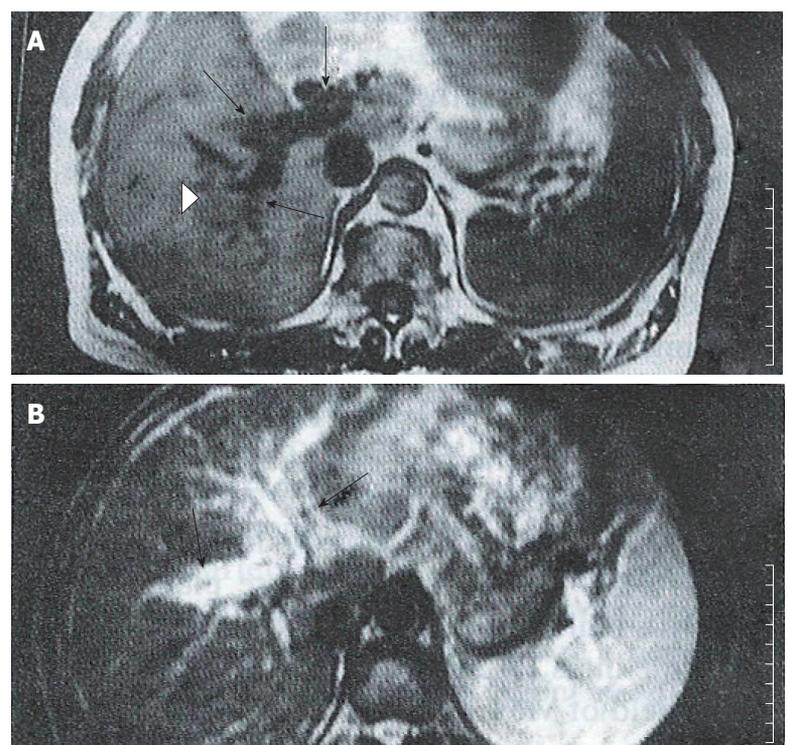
Patient with HCC. A: T1 weighed (500/15) images showed diffuse, irregular narrow right branches with numerous nodules (arrow); the distal portal vein was poorly delineated (arrowhead). Several small flowing voids representing collateral vessels were seen. B: T2 weighed (2000/80) MR images showed the left portal venous wall as slightly hyperintense, indicating invasion by the tumor (arrow).
